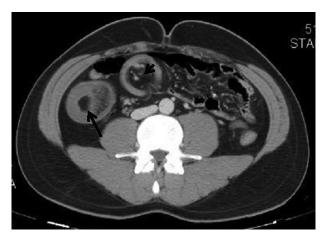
Distal axial CT slice. The linear densities representing the mesentery vessels differentiate the intussusceptum mesentery fat (short arrow) from the ileal lipoma (long arrow).
